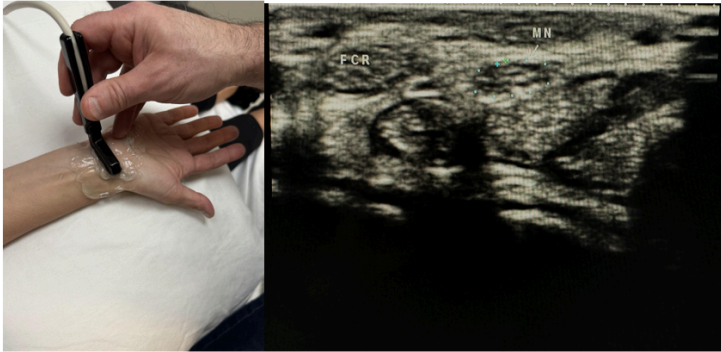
Side-by-side pictures of the transducer position and volar wrist showing the median nerve (MN) and flexor carpi radialis (FCR). The abbreviations given here and labeled on the ultrasound image represent the corresponding structures.
